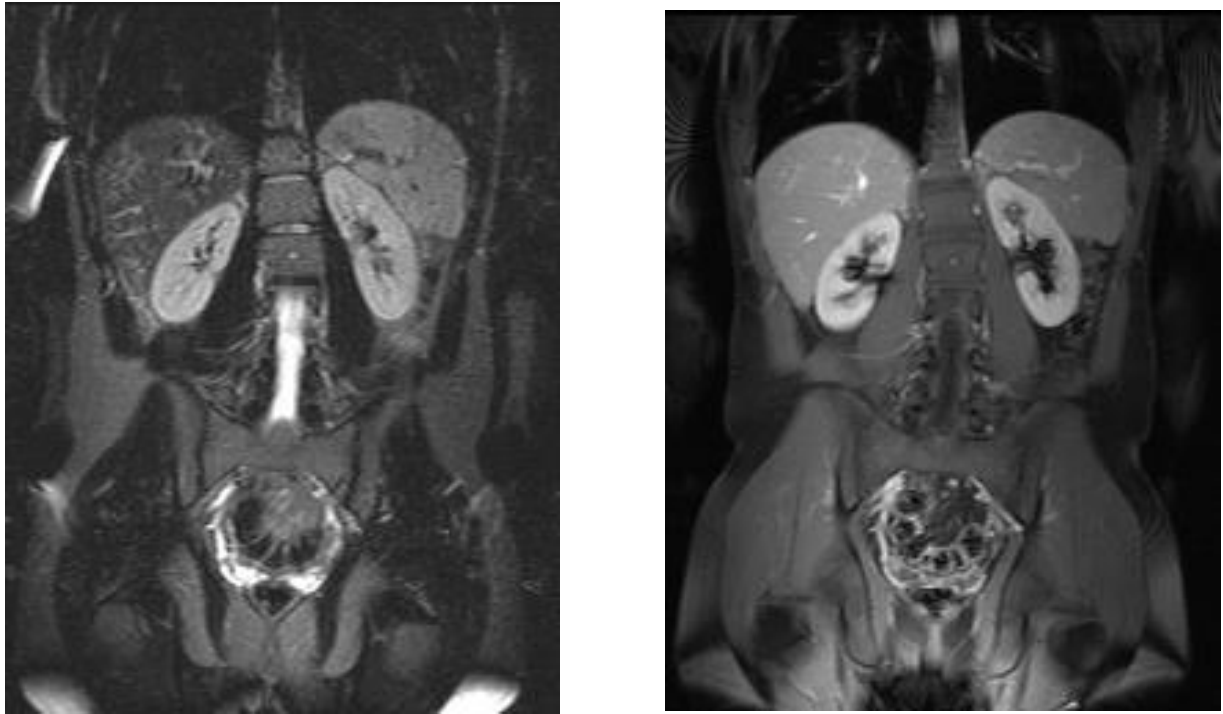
MRI abdomen, coronal, T2 STIR (left), T1 tse ce (right).
